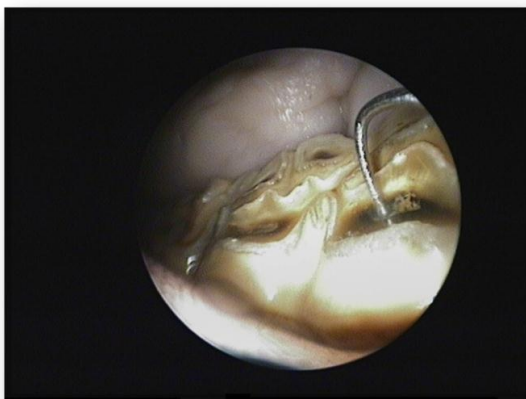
Orosopic image showing a defect of the secondary dentine with secondary food impaction and early caries often associated with apical abscessation. However despite the endodontic system being compromised, these findings may be incidental, and further information regarding any sub-occlusal reparative dentine formation is unknown from this image alone; radiographs recommended.
